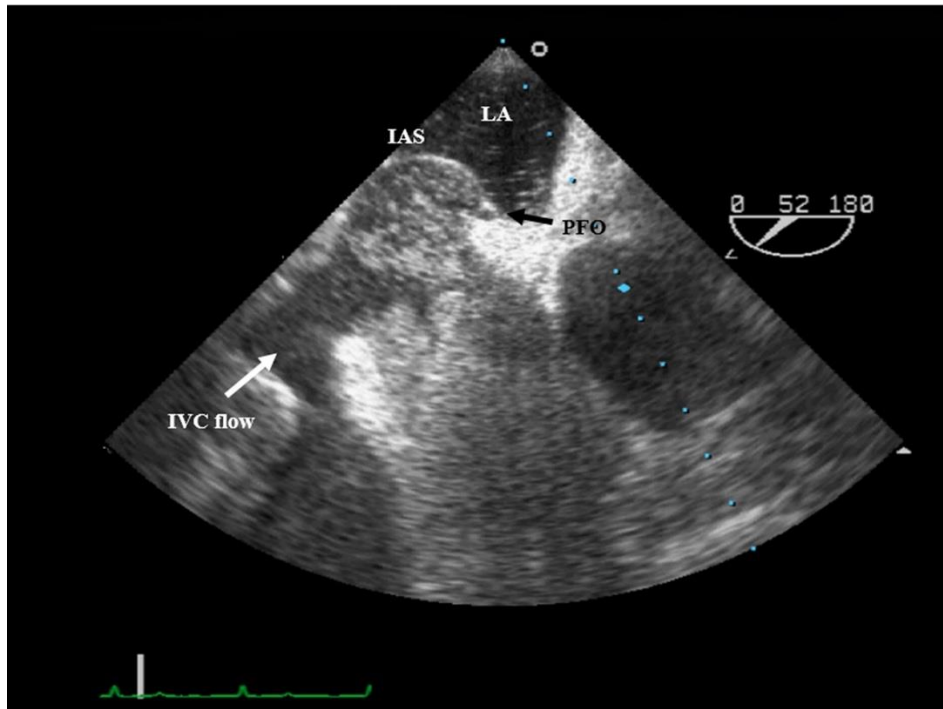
Transesophageal echocardiography in midesophageal short axis view showing flow from IVC creating a “washout” effect of the saline contrast. IAS, interatrial septum; IVC, inferior vena cava; LA, left atrium; PFO, patent foramen ovale
